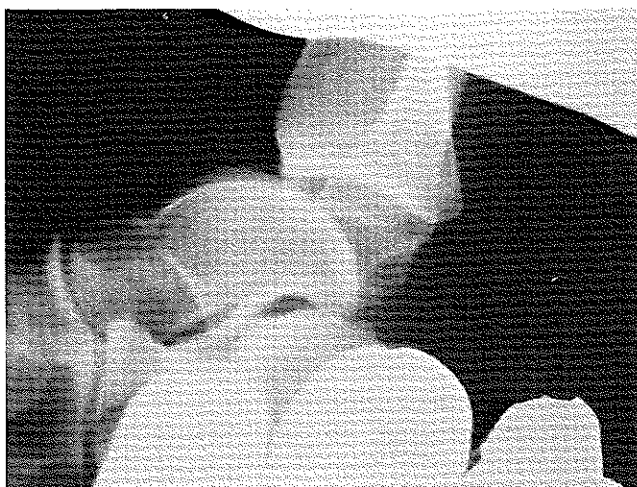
A positive anterior drawer radiograph.
